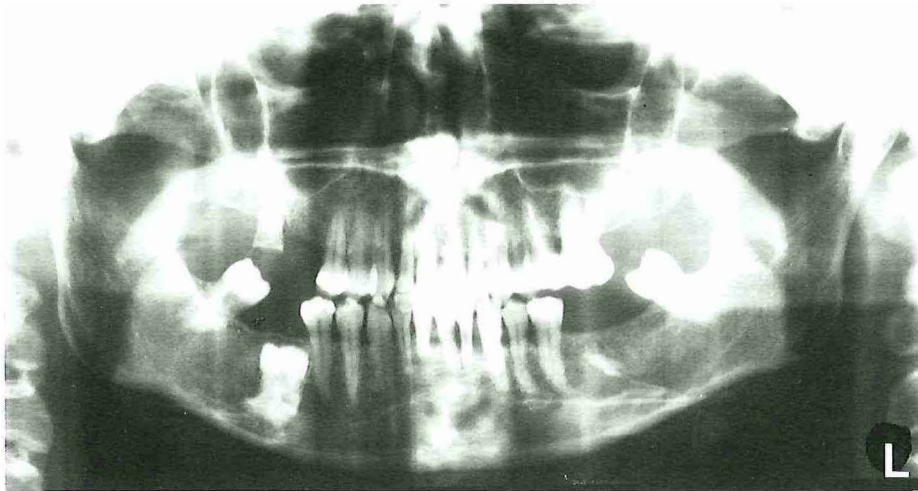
Orthopantomogram of a 36-year-old male showing primary retention of the mandibular right first molar with resorption of the crown and root.
